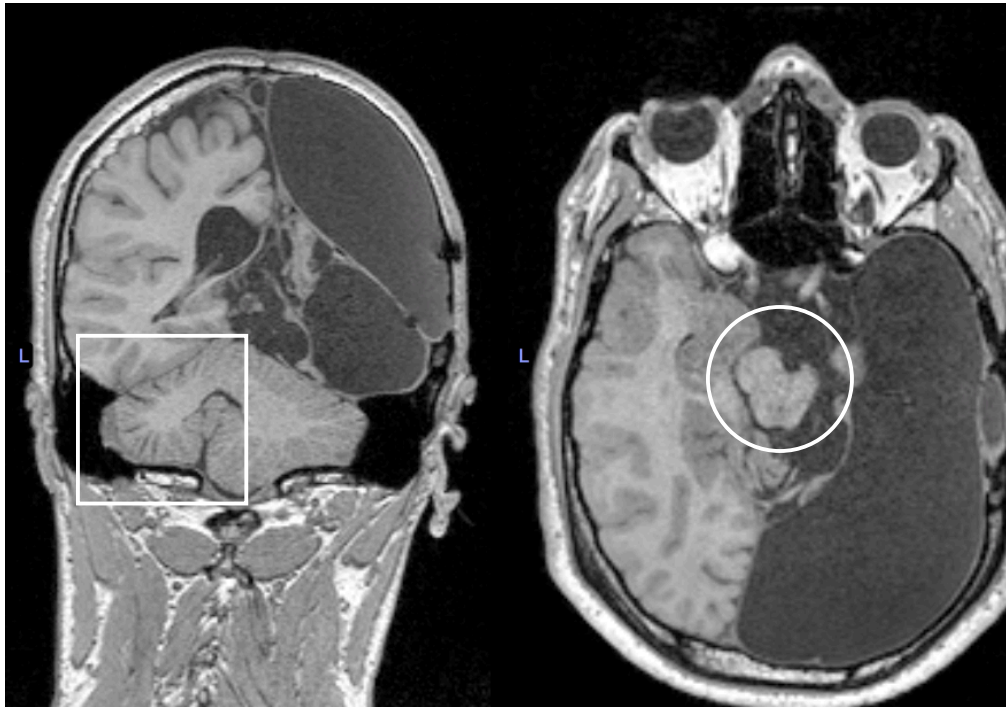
T1-weighted MRI: D.N.
